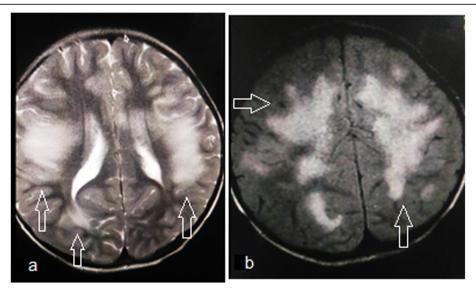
MRI brain demonstrates ADEM 2 pattern. a, b Bilateral rather symmetrical fronto-parietal periventricular white matter poorly demarcated patchy areas of abnormal signal high in T2W (a) as well as in FLAIR (b), impressive of demyelinating lesions
